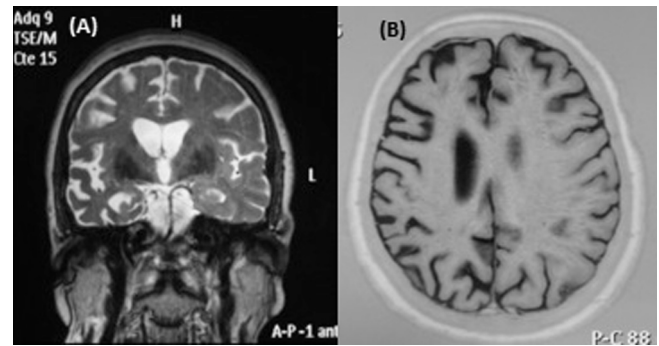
Cranial MRI showing predominantly right-sided frontotemporal lobar atrophy. (A) coronal, T2-weighted, (B) axial, T1-weighted.
